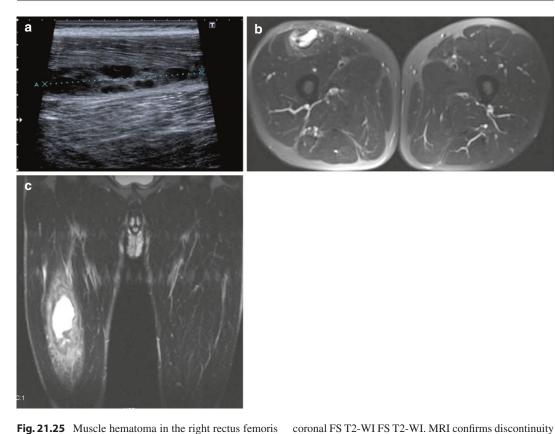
Muscle hematoma in the right rectus femoris muscle. (a) Sagittal ultrasound shows focal disruption of the muscle fibers (hematoma); (b) axial FS T2-WI; (c)
